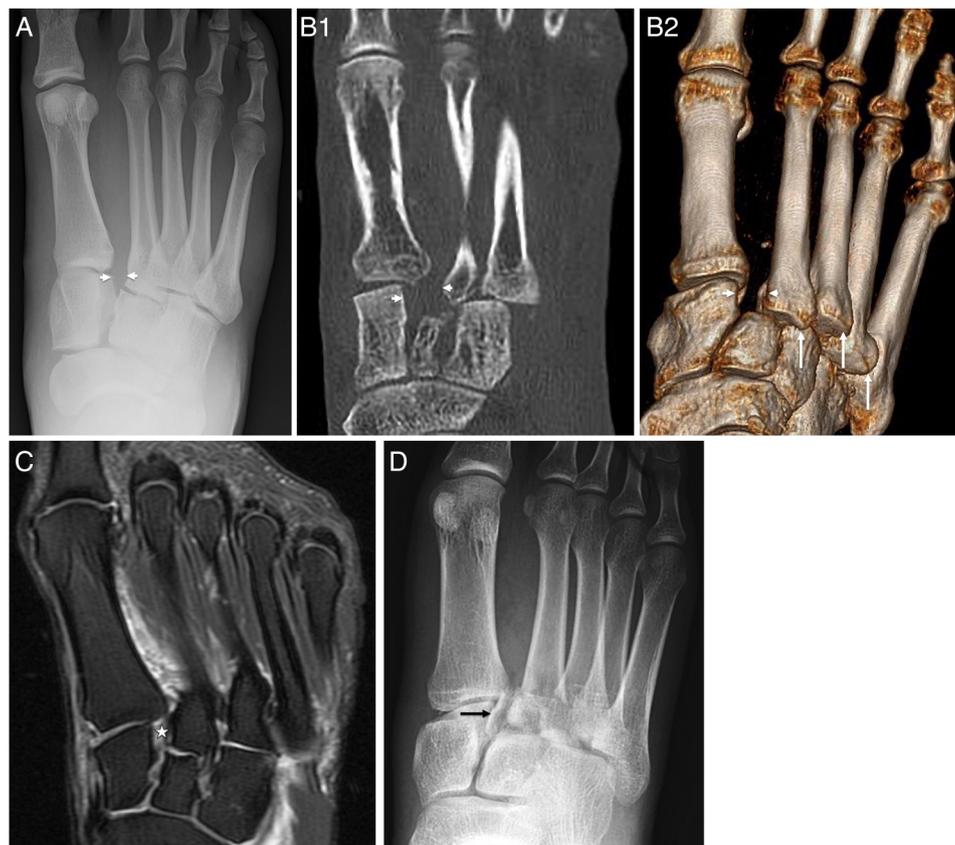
Lisfranc injury. Thirty-four-year-old male with pain following trauma. (A) Anteroposterior foot radiograph showing mild widening of the C1–M2 interspace (arrowheads) with incongruence at the second metatarso-phalangeal joint, suspicious of Lisfranc ligament injury. (B) Reformatted axial CT with volume rendering showing widened C1–M2 interspace (arrowheads). Volume rendered reformat demonstrates dislocation of the second, third and fourth metatarsal bases (arrows). (C) Axial fat-saturated proton-density-weighted image showing torn Lisfranc ligament in mid-segment with associated soft tissue oedema in the first–second intermetatarsal space (star). (D) Different patient (36-year-old male) with Lisfranc injury including fracture at the base of the second metatarsal, *fleck sign* (arrow).
